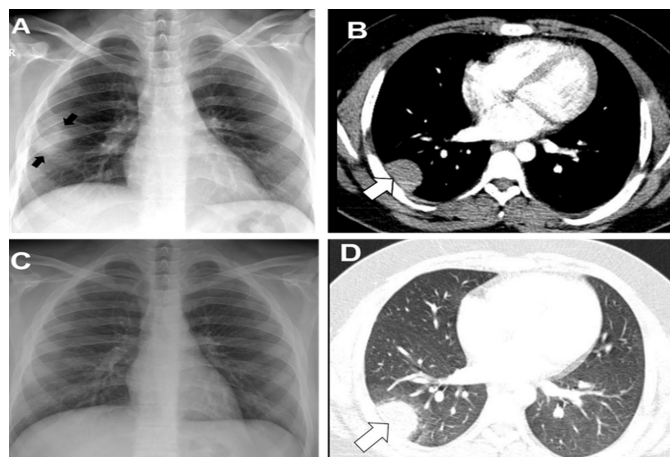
A round pneumonia lesion in a 16-year-old boy. Initial posterioranterior chest radiography (A) and chest CT images (B, mediastinal window, D, lung window) show round foci of opacity (arrows) in the right upper lobe. C. Chest radiograph obtained 4 weeks later reveals resolution.
